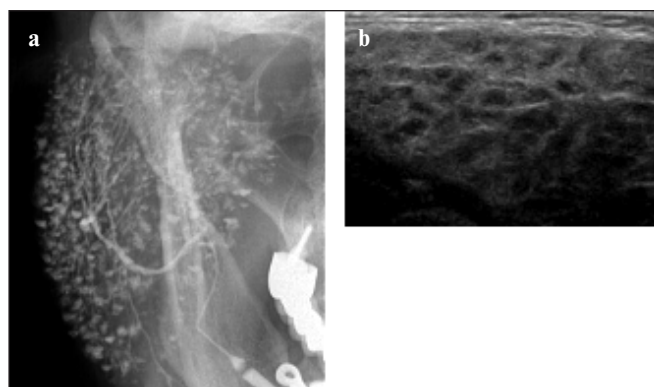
Sialography (a) and ultrasonography (b) of the SG in patient B., 55 years old
